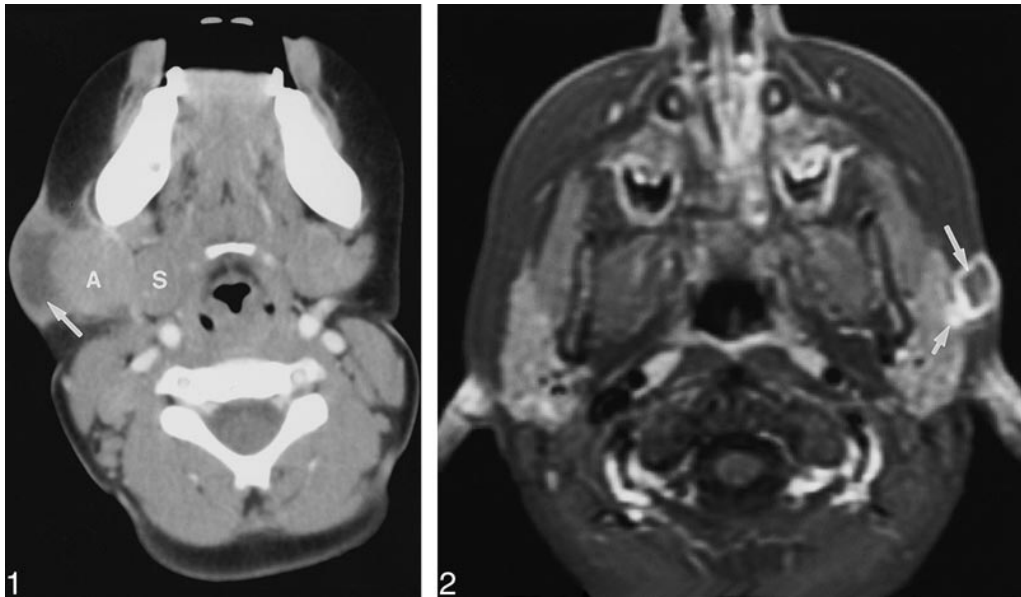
Case 1: Girl, 2 years six months old, with nontender right submandibular mass. Axial contrast-enhanced CT scan shows medial displacement of right submandibular gland (S) by right submandibular adenopathy (A). Suppurative granulomatous material represented by low-density ring-enhancing subcutaneous mass (arrow) extending from adenopathy to skin. Minimal stranding of adjacent subcutaneous fat is present.
